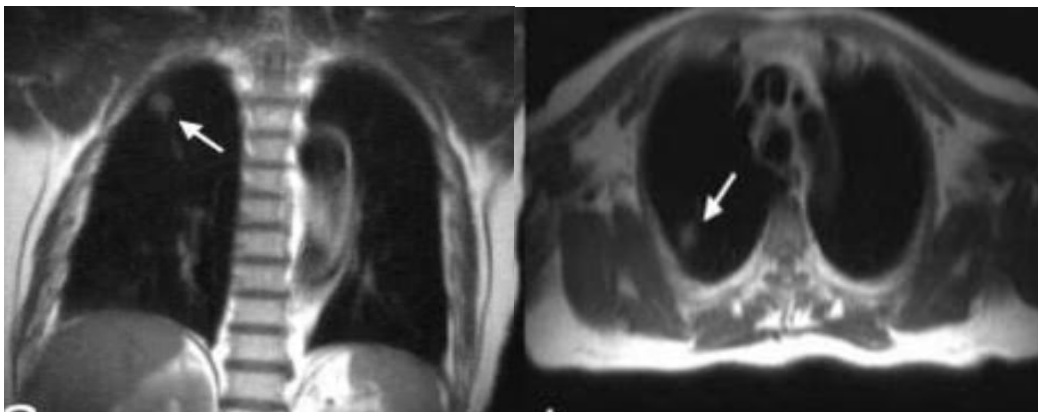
MRI breast study of 44 years old female patient with left breast two suspicious looking masses with left suspicious axillary lymph nodes. (BI-RADS-5) with axial and coronal sequences showed right upper lobar apical nonspecific pulmonary nodule.
